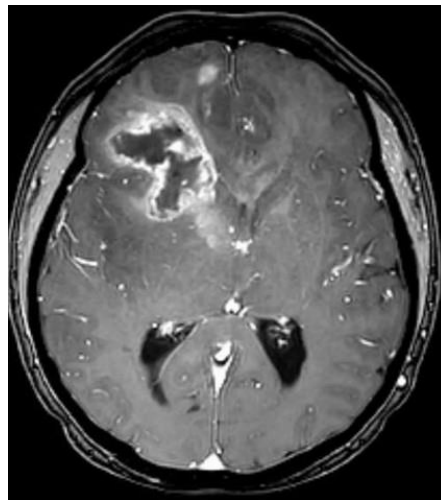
Brain MRI (magnetic resonance imaging) with T1-weighted contrast-enhanced (T1CE) showing a glioblastoma in the right frontal lobe⁸. Note the heterogeneous irregular peripheral enhancement with a central non-enhancing area, consistent with necrosis.
